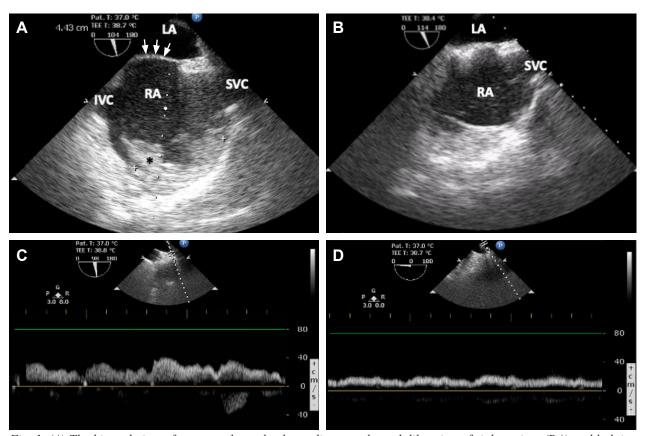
(A) The bicaval view of transesophageal echocardiogram showed dilatation of right atrium (RA) and bulging of septal wall to the left atrium (LA) (arrows). A large thrombus (asterisk) of 4 cm in length was noted in the right atrium. (B) The RA thrombus was undetectable under echocardiography 15 min later and followed by another episode of hypotension. Pulsed-wave doppler measurement of flow velocity at the orifices of right upper pulmonary vein (C) and left upper pulmonary vein (D). The flow velocity was about 40 cm/s in the right pulmonary vein, but was almost diminished in the left pulmonary vein. IVC: inferior vena cava; SVC: superior vena cava.
